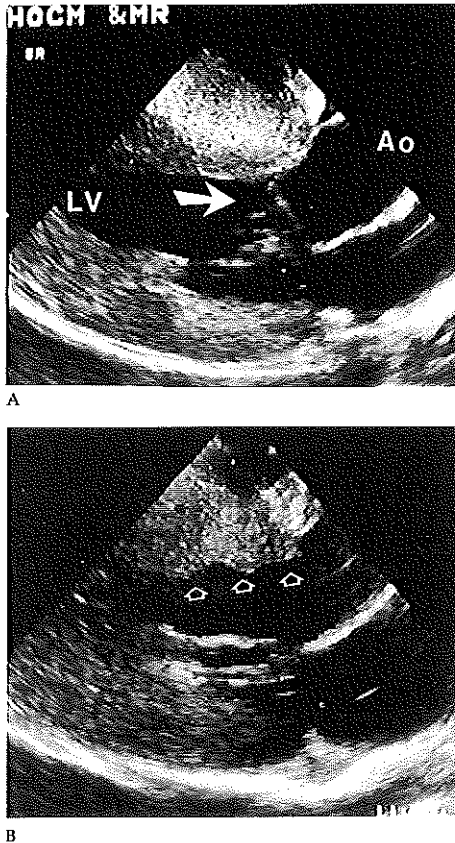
Epicardial echocardiograms in the left ventricular long axis, before (A) and after (B) spark erosion myectomy and patch plasty of the mitral valve. Systolic frames with an open aortic valve. (A) The closed arrow points to the area of systolic anterior motion of the anterior mitral valve leaflet. (B) The open arrows point to the site of myectomy. Systolic anterior motion has completely disappeared. (Ao = aorta; LV = left ventricle; HOCM = hypertrophic obstructive cardiomyopathy; MR = mitral valve regurgitation.)
